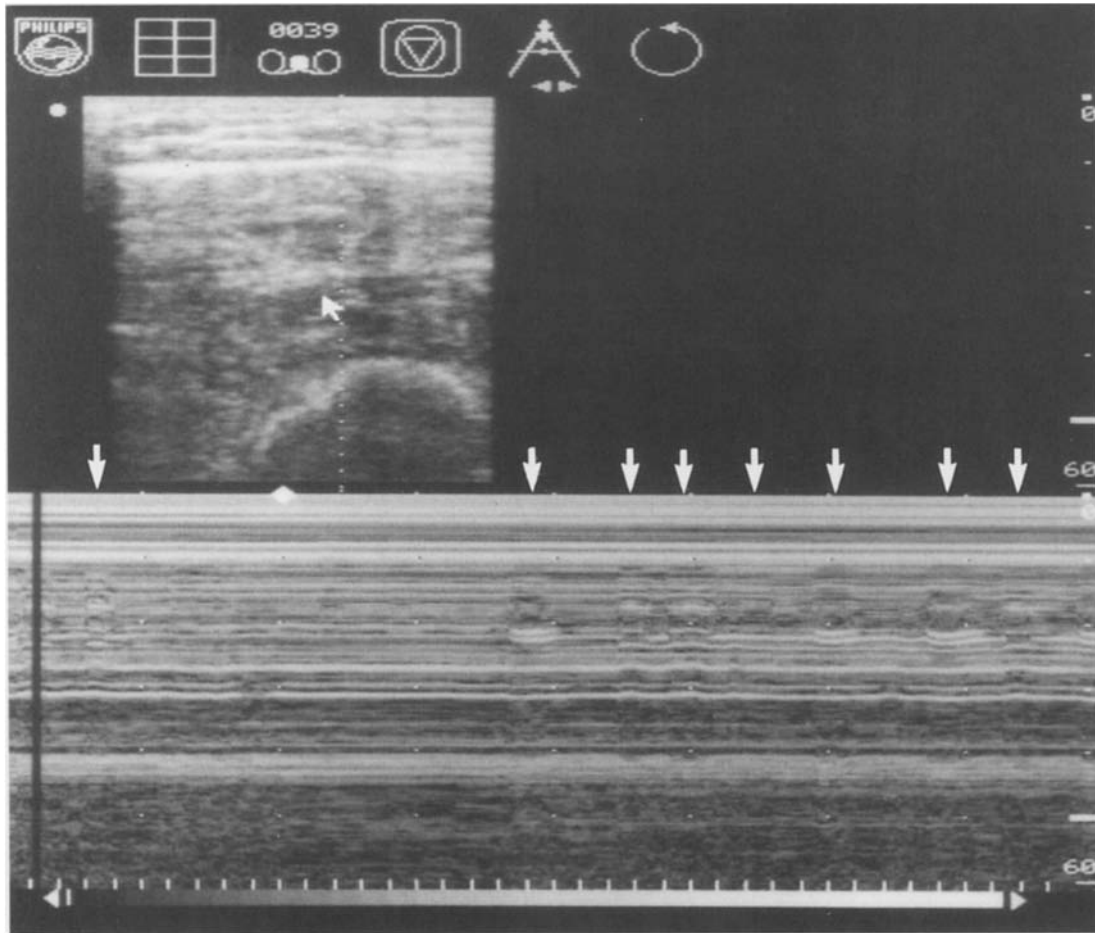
B-mode (*upper section*) and M-mode ultrasonography of the right rectus femoris and vastus intermedius muscles in a patient with lower motor neuron disease: at least 8 short muscle twichings (indicated by the *arrows*) within 8 s were recorded
